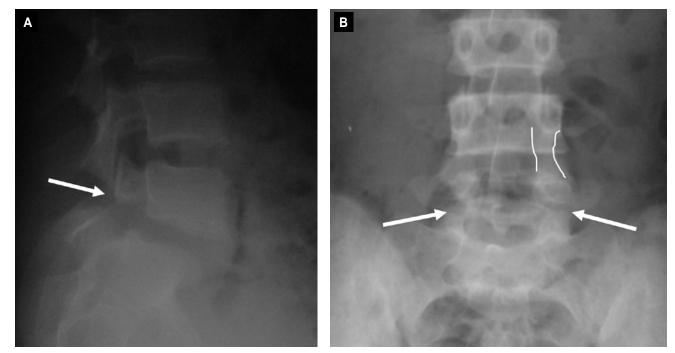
(left). Lateral X-ray confirming sclerotic defect just inferior to the pedicle Figure 1b (right). AP X-ray indicating the intact L4 pars between the white lines, whereas the L5 level suggests a defect as indicated by the arrows
